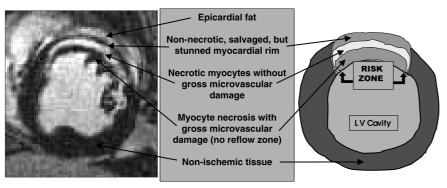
Relationship of magnetic resonance imaging contrast enhancement patterns (IR FLASH image left panel) to textbook definition of myocardial regions associated with ischaemic injury (right panel). (Right panel adapted with permission from Heart Disease: A Textbook of Cardiovascular Medicine, 5th edn, 1997.)
